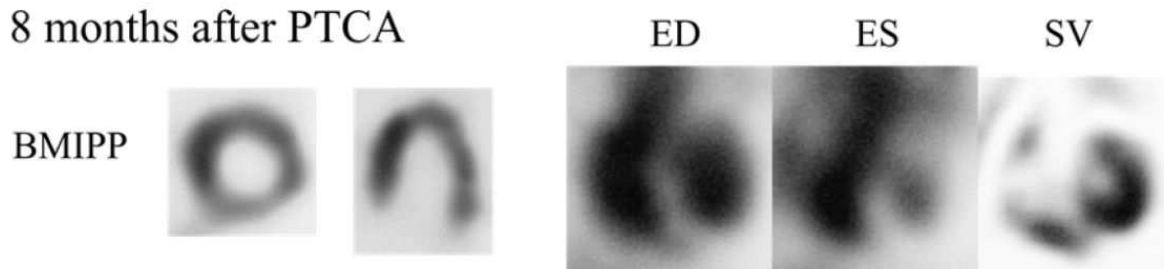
Short axis and horizontal long axis slices of ^{201}Tl , ^{123}I -BMIPP and gated blood pool images. The patient with angina pectoris underwent thallium and BMIPP SPECT. Discordant BMIPP uptake less than thallium in antero-lateral wall was observed (arrows). Gated blood pool scintigraphy demonstrated mild hypokinesis in antero-lateral wall. Stroke volume image showed reduced stroke volume in anterolateral wall (arrow). Coronary angiography showed severe stenosis of the first diagonal branch of the left anterior descending coronary artery. Coronary angioplasty was successfully performed and BMIPP uptake and wall motion abnormality improved 8 month later. The discordant BMIPP uptake less than thallium depicted the dysfunctional but viable myocardium or hibernating myocardium in antero-lateral wall. ED = end-diastolic, ES = end-systolic, PTCA = percutaneous transluminal coronary angioplasty, SV = stroke volume
